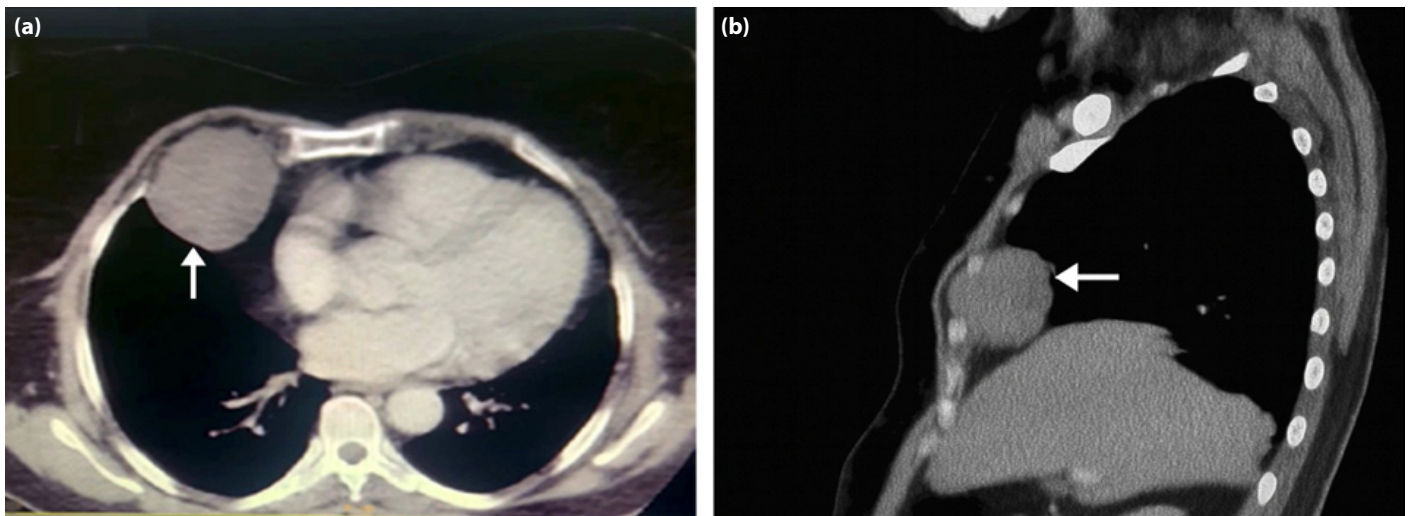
(a) Axial view and (b) sagittal views of contrast-enhanced chest computed tomography demonstrating a well-defined, encapsulated mass located in the right third intercostal space, without invasion of adjacent tissues.
